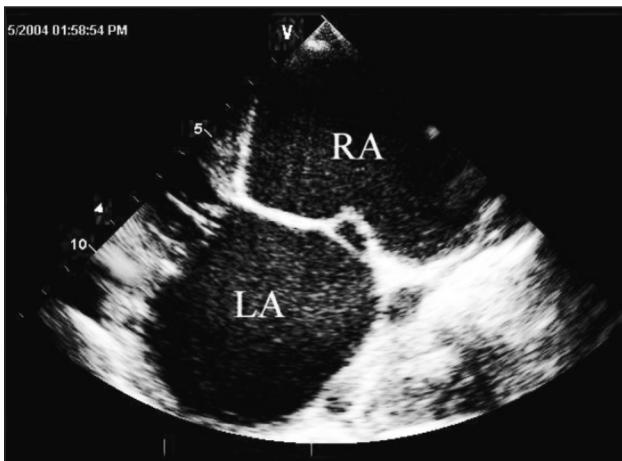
Right parasternal long-axis view demonstrating biatrial enlargement. RA, right atrium; LA, left atrium.
